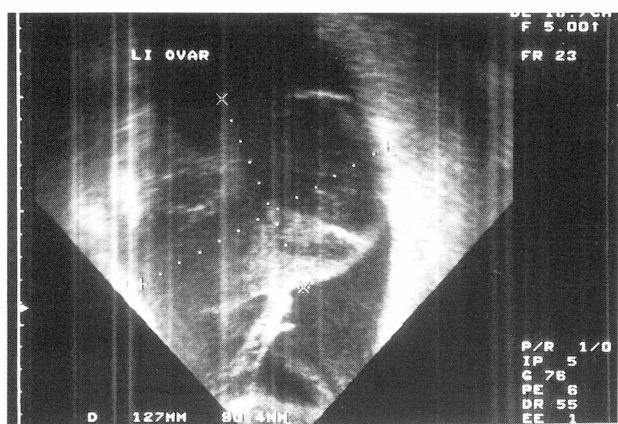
Patient 2. Vaginal sonogram shows left ovarian cysts up to 6 cm in diameter and ascites.
